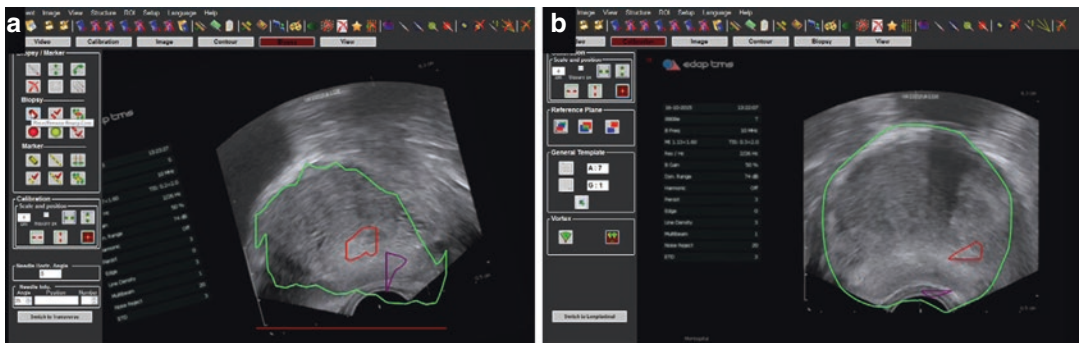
Superimposition of MR and US images: the outer shape of the prostate is used to match the MRI contour to the real-time US image. (a) Longitudinal view; (b) transversal view
